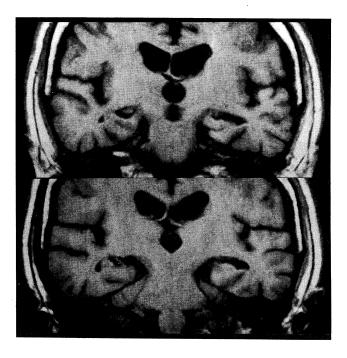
Coronal view of MR imaging scan reveals bilateral atrophy of the hippocampus.
